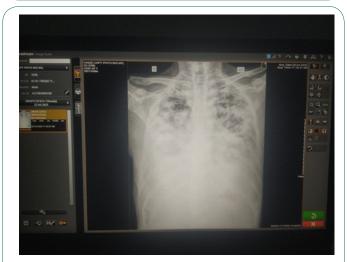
Chest radiograph showing cardiomegaly, bilateral pleural effusion, multiple alveolar shadows over both lungs.
